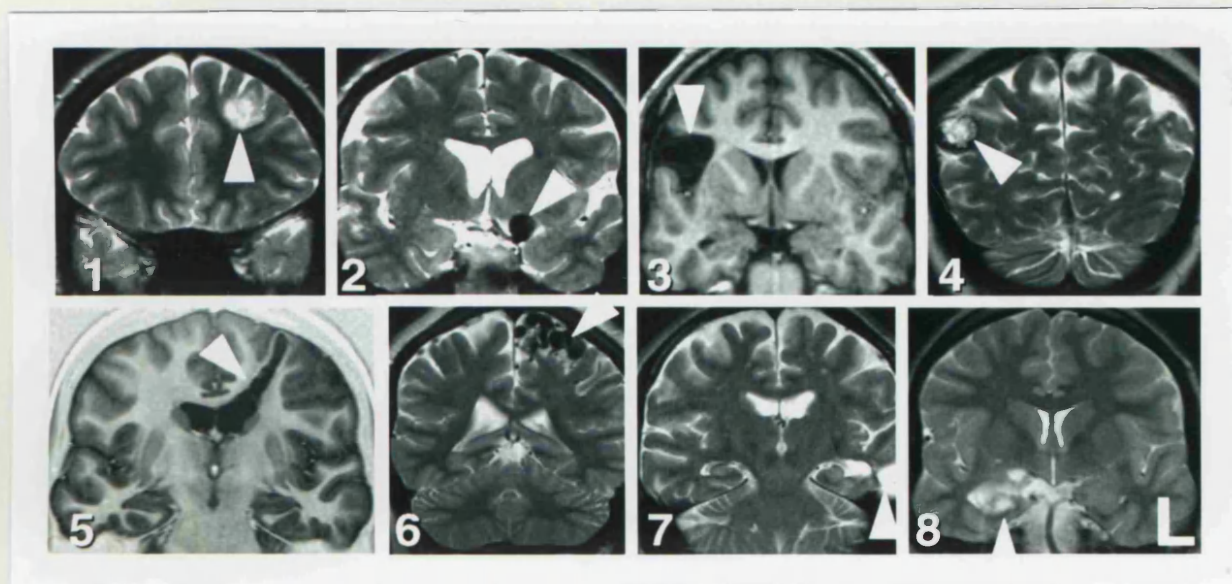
Lesions other than HS in adults with newly diagnosed localization-related epilepsy. All lesions are indicated by white arrows. 1, 2, 4,6-8: T2-weighted images (TE = 80 msec), 3 and 5: IR T1-weighted images. 1. Mass lesion in left frontal lobe, possibly a DNET [Hospital number: QSC16548]. 2. Giant aneurysm of the left terminal internal carotid [Hospital number: QSC23328]. 3. Widening of the sylvian fissure returning signal similar to CSF suggesting an extrinsic lesion such as an arachnoid cyst or a cisternal epidermoid. 4. Cavernous angioma. 5. Patient with stroke-like episode with sudden onset aphasia resolving over 8 weeks, and first right adverse seizure with secondary generalization 7 months later. The MRI shows an unusual prominent linear abnormality extending from the pial surface to the ependyma which is associated with tissue loss. The appearance suggests brain damage of uncertain cause, possibly an unusual infarct [Hospital number: QSC30152]. 6. Arteriovenous malformation. 7. Post traumatic scar. 8. Mass lesion involving right mesial temporal structures, possibly low-grade glioma or DNET [Hospital number: QSC27119].
